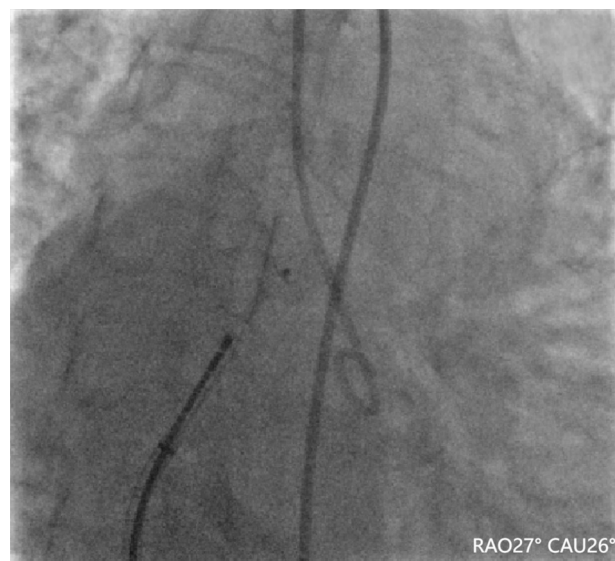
A 260-cm J-tipped guide wire was then carefully withdrawn after confirmation of successful closure via X-ray
